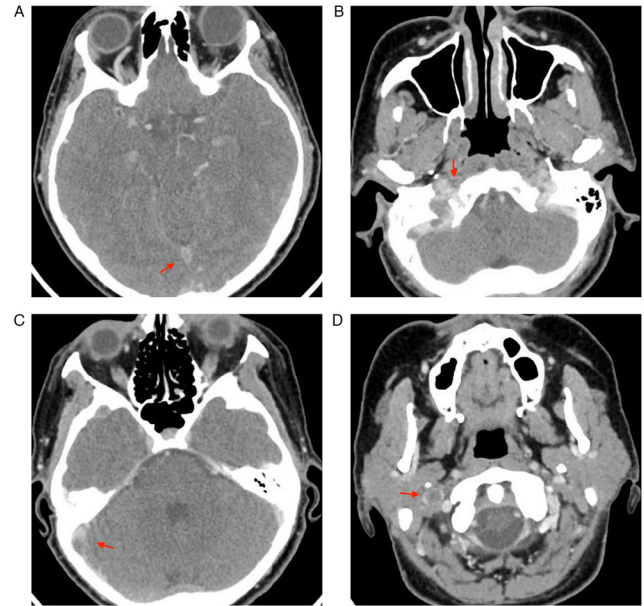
Case 2. (A) CT cranial angiography performed on the first day of hospitalization indicated thrombosis of the superior sagittal transverse (red arrow); (B) thrombosis of the right sigmoid sinuses (red arrow); (C) thrombosis of the right transverse sinus (red arrow); (D) thrombosis of the right jugular vein (red arrow).
